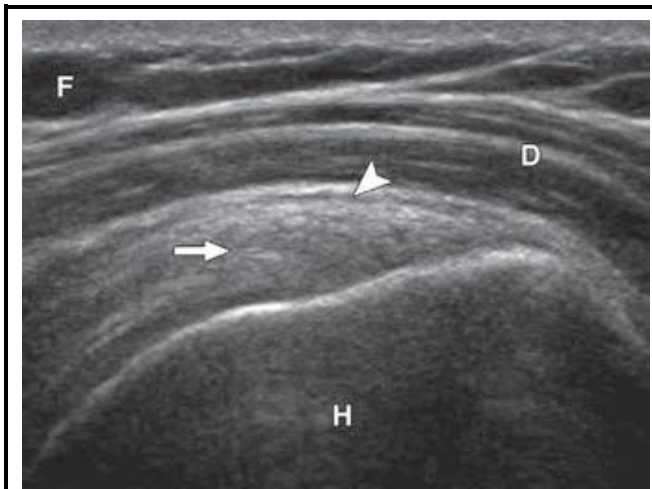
30-year-old woman with normal shoulder. Ultrasound image of supraspinatus tendon (long axis) shows normal hyper echoic and fibrillar supraspinatus (arrow).
